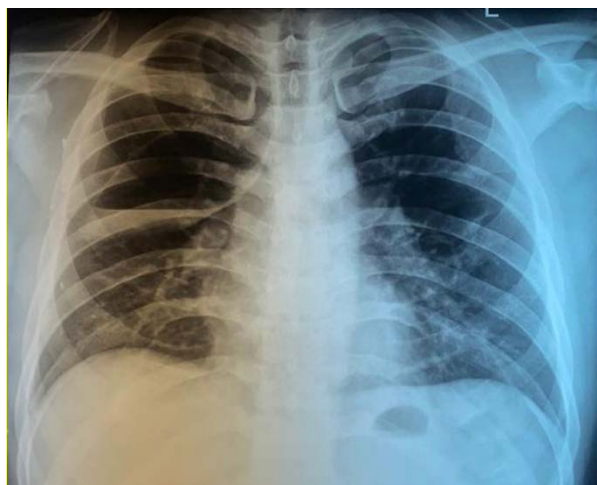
Chest x-ray evaluation showed bronchopneumonia bilateral and suggestive minimally right pleural effusion
